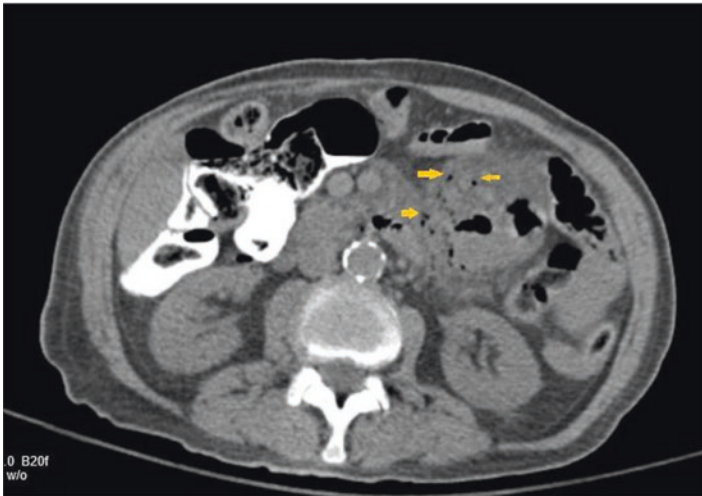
CT imaging of endoscopic-related perforation evidenced by free air (arrows)
